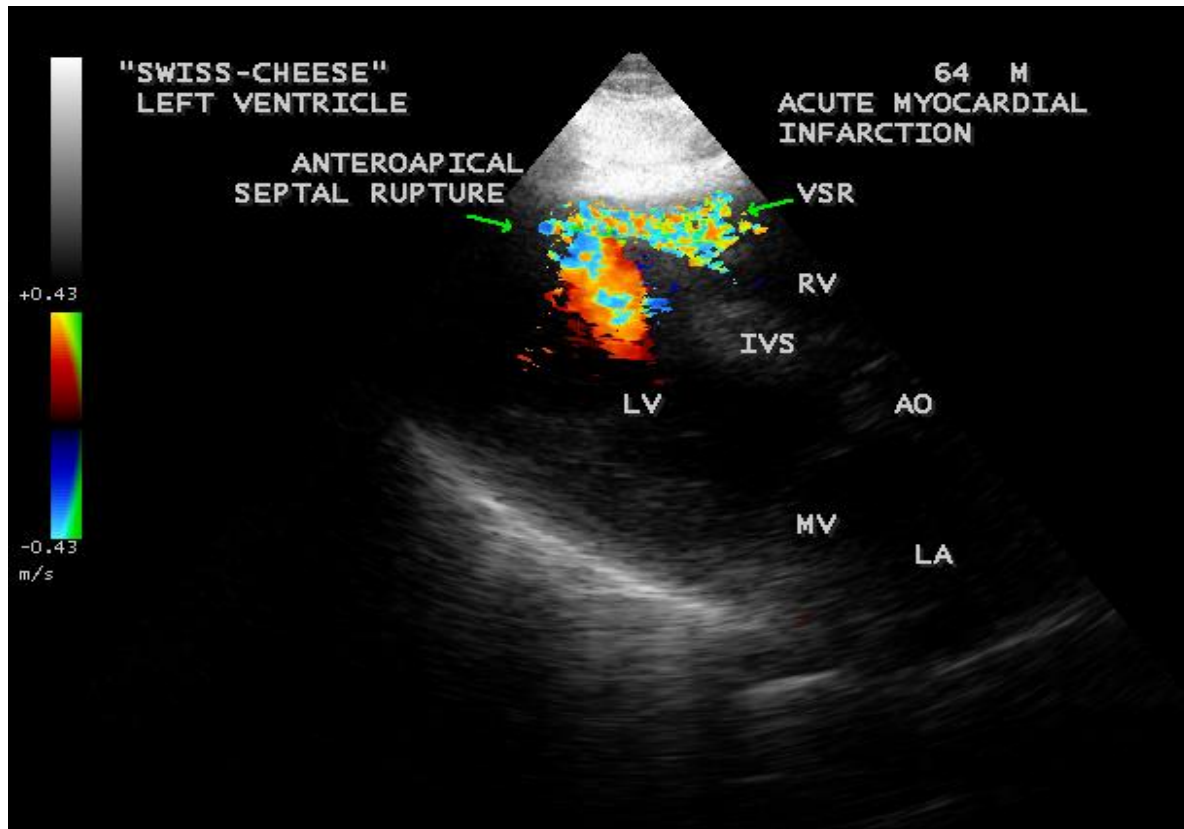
Parasternal long axis view showing the anteroapical ventricular septal rupture.
